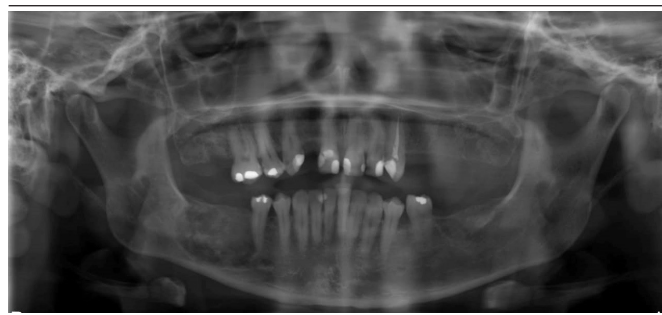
Radiographic findings of the lesion. Radiolucent image showing radiopaque foci, with well-defined limits, in the right region of the mandibular body
